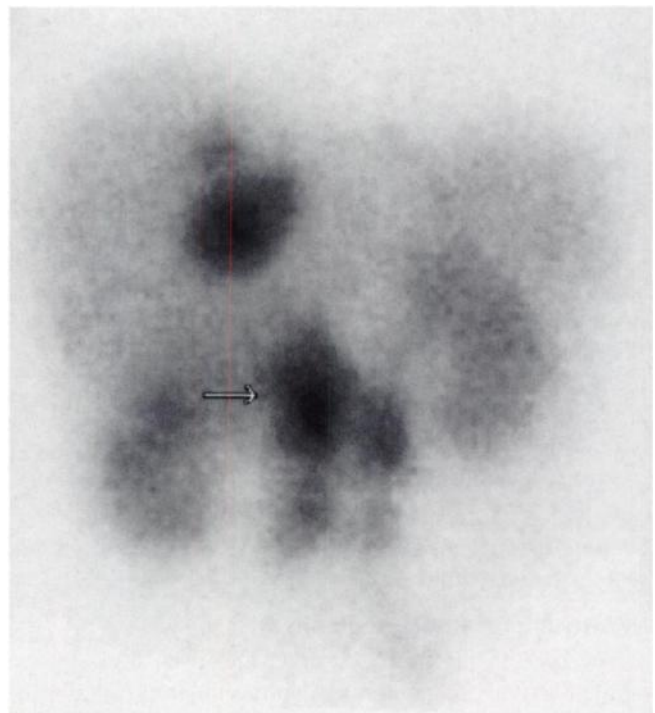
Reconstructed SPECT coronal view over abdomen of patient with midgut carcinoid tumor metastasized to liver. Primary tumor is indicated by arrow. Tumors were verified by surgery.
